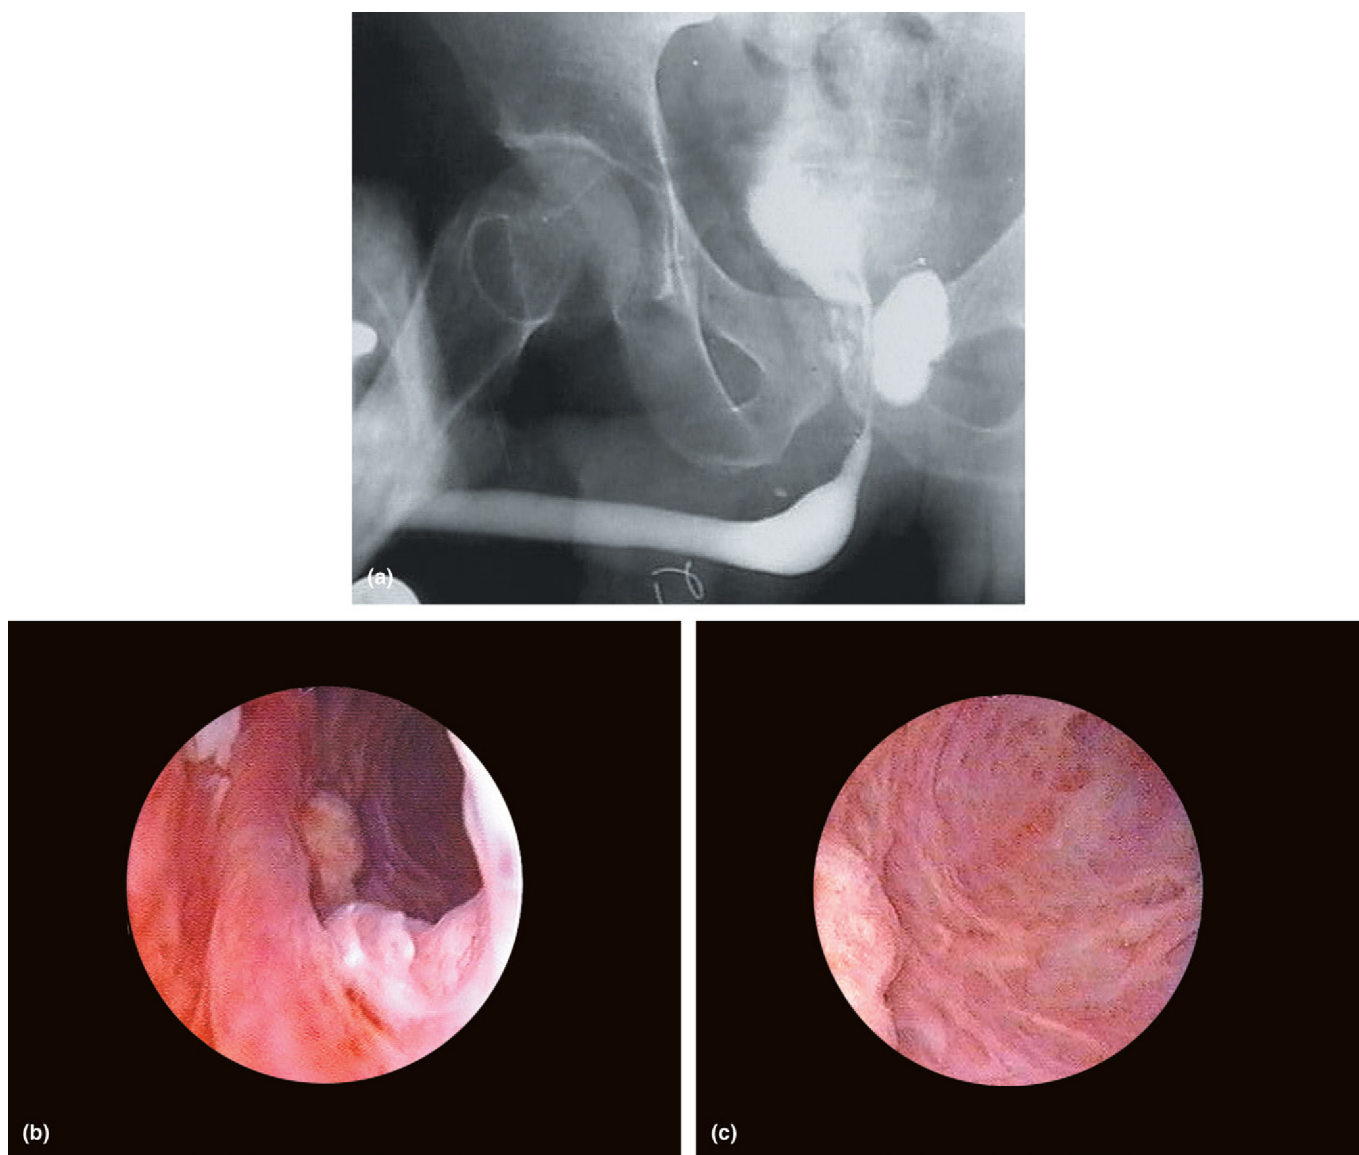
Large prostatic lithiasis discovered by chance. (a) Pelvis radiography; (b, c) intraoperative aspects; and (d) stones extracted at the end of the intervention.
